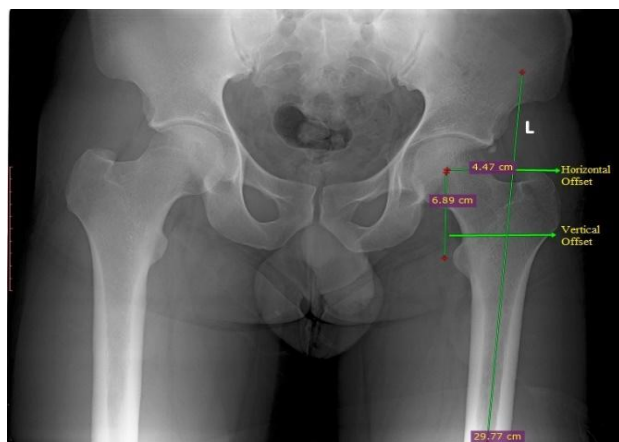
Sagittal X-ray of Hip showing Horizontal and Vertical axis
